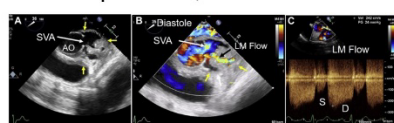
Admission 2. Mid-esophageal TEE two-dimensional, color Doppler, and continuous-wave Doppler images. (A) Short-axis image of the aortic root shows a large left SVA due to patch dehiscence. The ostium of the SVA is shown by a large arrow, and its extent by yellow arrows. (B) Color flow imaging shows emptying of SVA in blue in diastole (arrow). The extent of the SVA is shown by yellow arrows. Turbulent, mosaic color, high-velocity flow (black arrow) suggests LM obstruction due to extrinsic compression. (C) Color-guided continuous-wave Doppler examination of the LM flow shows mildly increased systolic (S) and very high diastolic (D) velocity of ~2 m/sec. The LM is very long, and no left circumflex is noted. Findings are consistent with LM compression and likely left circumflex occlusion. AO, aorta.
